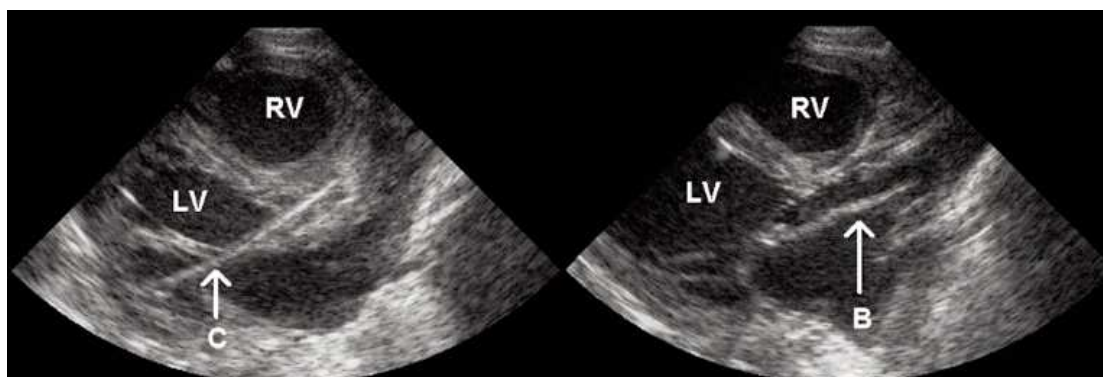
Echocardiographic images when endhole catheter and Tyshak balloon were passed through the aortic valve. The balloon was inflated. LV, left ventricle; RV, right ventricle; c, catheter; b, balloon.
